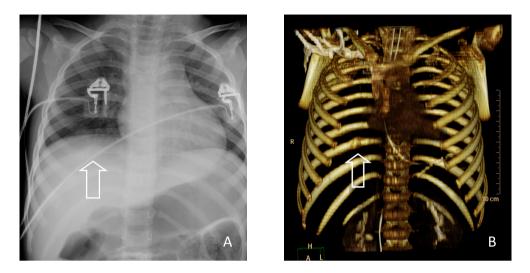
Chest radiograph in a 3-year-old girl, victim of inflicted traumatic brain injury, who was admitted to the hospital in a comatose situation. A consolidating posterior rib fracture is shown (arrow). Figure 2b. Threedimensional reconstruction of the chest CT (shaded surface display) clearly demonstrates the posterior rib fracture on the right side (arrow).
